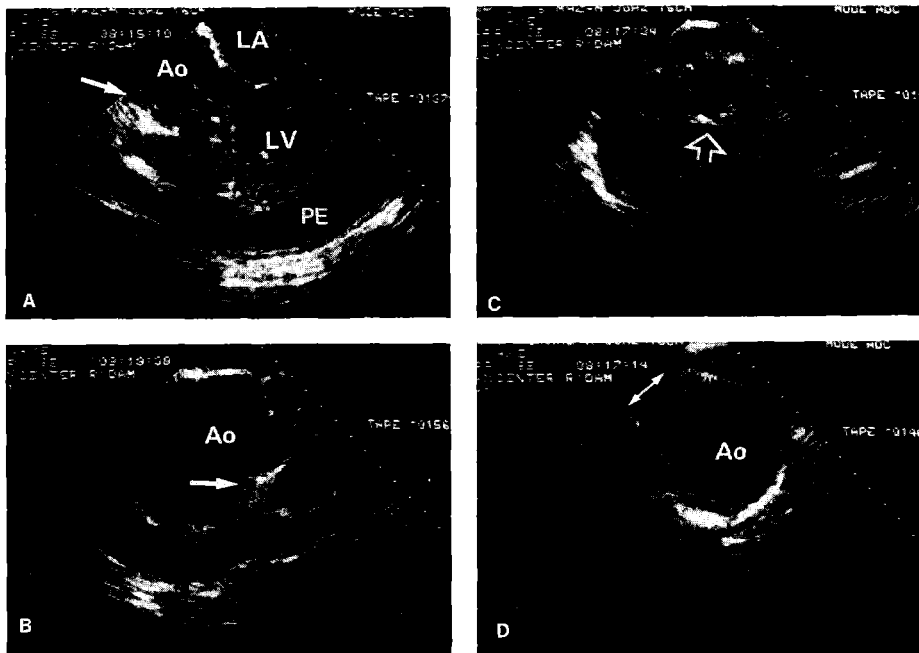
Transesophageal two-dimensional echocardiograms (5 MHz transducer) obtained in a patient with a history of infective endocarditis. A, The long-axis view shows an apparently normal intracardiac geometry surrounded by a large amount of pericardial effusion (PE). B, Directing the beam to the aortic (Ao) root, a huge ascending aorta is visualized. Serial cross sections in this region revealed highly reflective echo structures (A and B, arrow) in the area of the right sinus of Valsalva. C, A mass lesion is seen within the dilated aorta which has "soft" echo characteristics (open arrow). D, A further superior tilt of the transducer shows a normal caliber of the ascending aorta distal to the dilated part (arrow). Abbreviations as in Figures 1 and 2.
